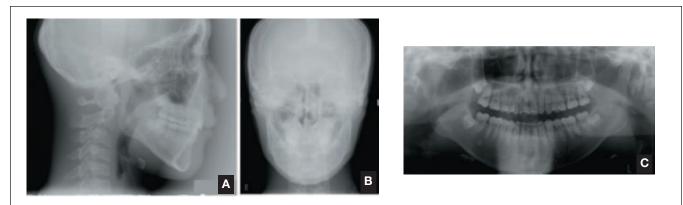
Posttreatment radiographs; A, lateral cephalogram; B, posterioanterior cephalogram; C, panoramic radiograph.
